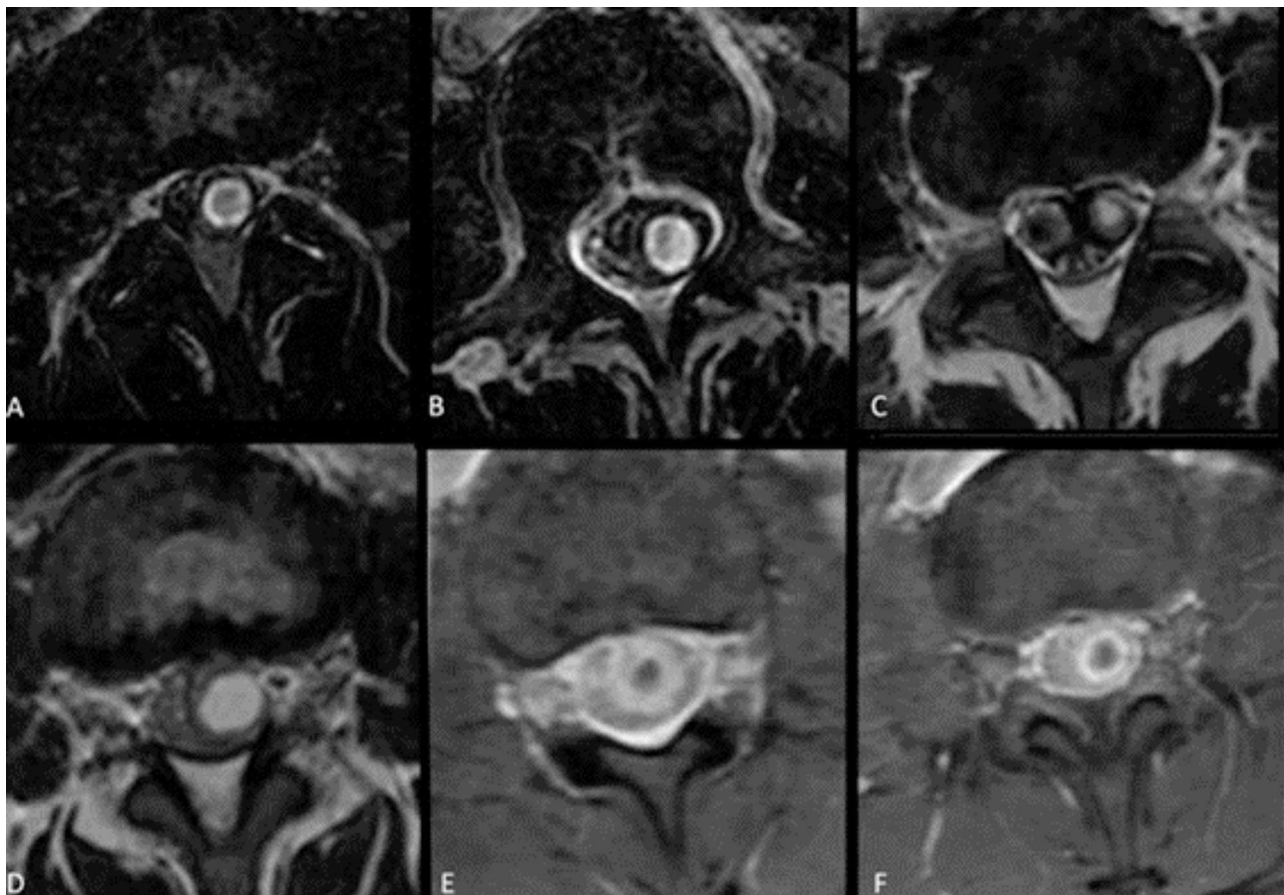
Spinal cord MRI. Axial images of the thoracolumbar spine. A- T2 Fat Sat, B & C-T2. Lower row post-contrast, D-T1, E & F-T1 Fat Sat. There are nodular intradural extra-axial lesions with heterogeneous T2 signal and variable enhancement (solid in D, peripheral in E and F)
